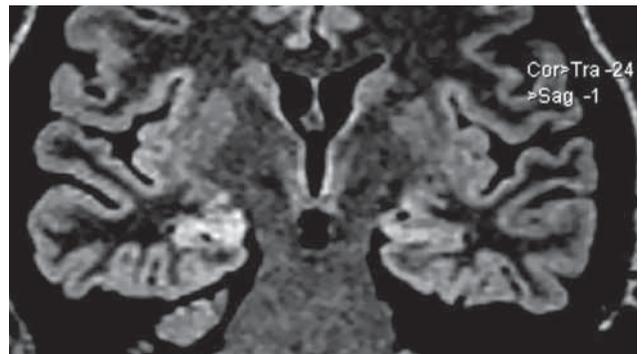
Right hippocampal sclerosis (MRI 1.5T)
